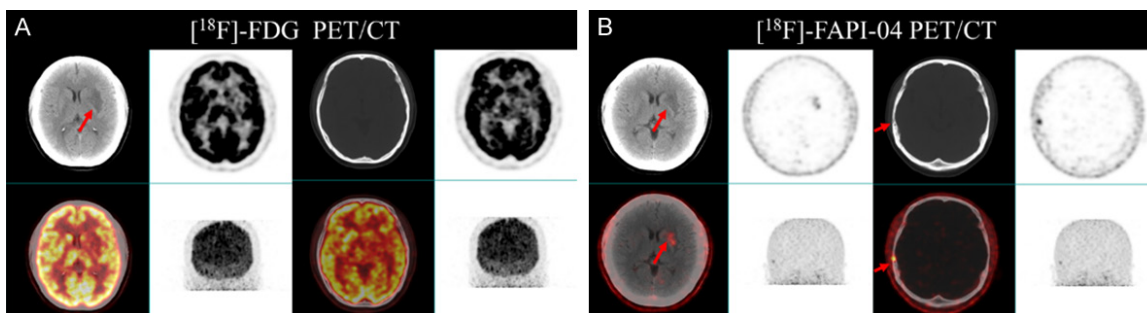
Detection results of head metastatic tumor. A 45-year-old female hospitalized with a 3-month history of cough and malaise. Chest CT revealed a dense shadow in the lower lobe of the right lung. Following anti-inflammatory treatment, a repeat CT scan was performed, and malignancy was suspected. Further evaluation with [¹⁸F]-FDG PET/CT and [¹⁸F]-FAPI-04 PET/CT was performed before treatment. A. FDG: Slightly hypodense nodule in the deep left frontal lobe, abnormal radioactive concentration in PET, SUVmax: 7.6. No abnormalities in bony structures. B. FAPI: Slightly hypodense nodule with abnormal radiolucency of PET seen in the deep left frontal lobe SUVmax: 2.1. Abnormal concentration in the right temporal bone SUVmax: 6.2.
